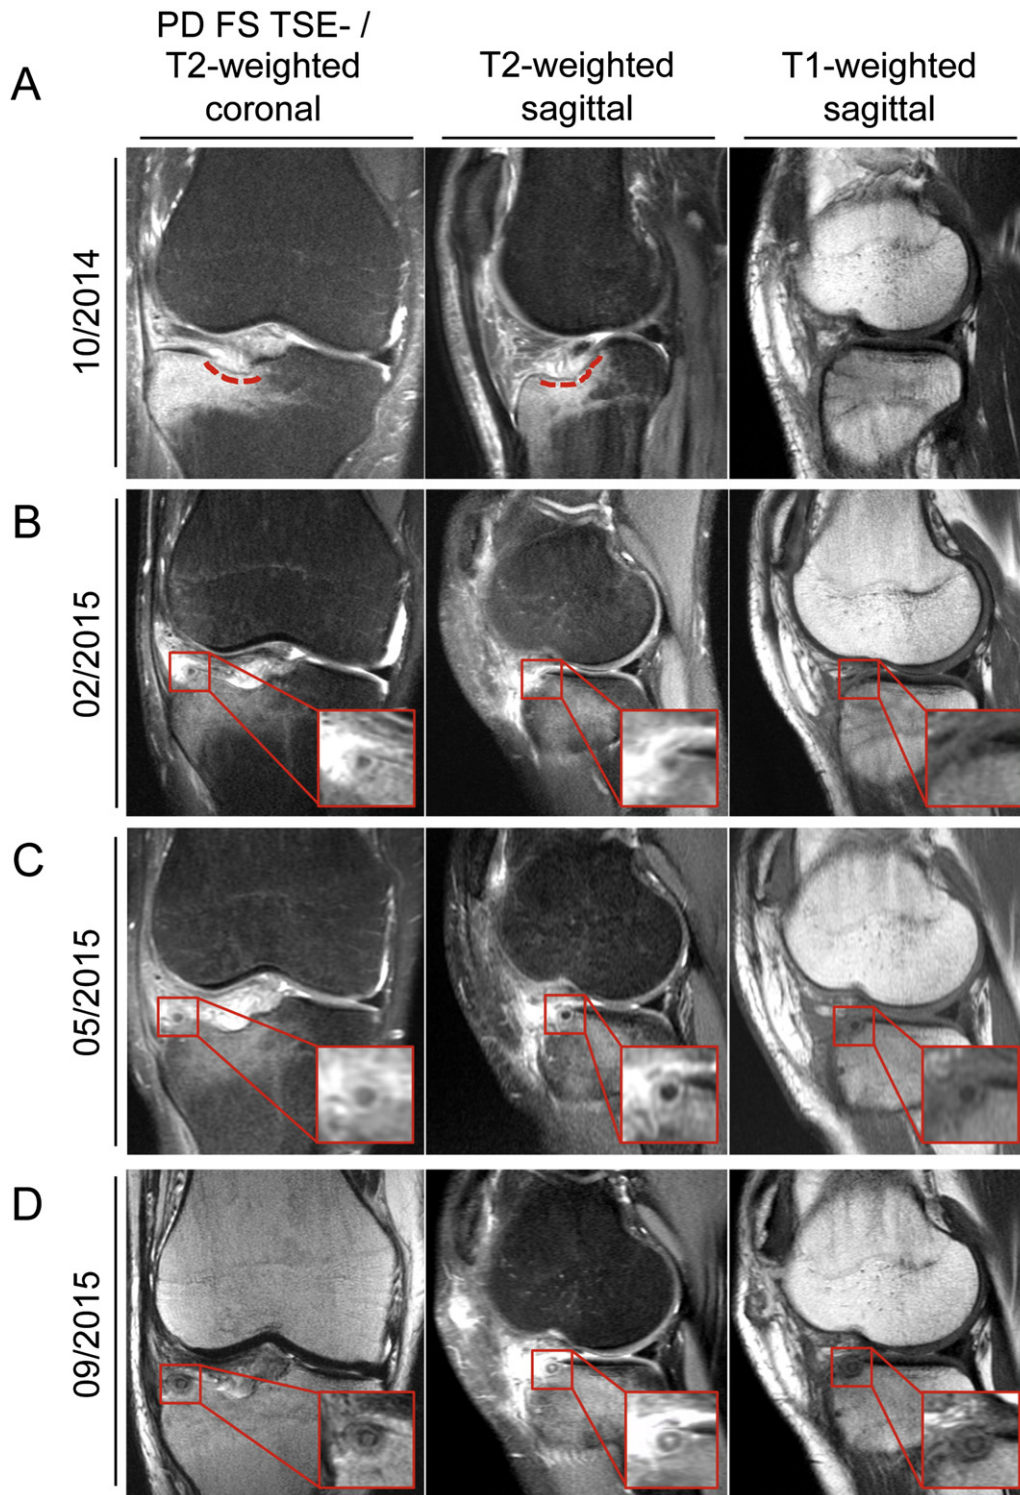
MRI specific characteristics of iaOO progression. Fat suppressed (FS), proton density (PD) weighted, turbo spin echo (TSE) MRI images show an ill-defined high intensity signal of the subchondral bone in the lateral tibia plateau without a specific focus. An old submeniscal bone impression in the antero-central region of the lateral tibia plateau can be seen (dotted line, A). Four months later, PD FS TSE- and T1-weighted TSE images show a poorly demarcated, semi-round lesion with a hypointense center and a diffusely enhanced signal surrounding the nidus (B). Another three months later, the central low signal and its rim enhancement became sharper. A minor, fusiform low intensity signal accompanies the hyperintense rim (C). In the final stage, the central nidus with its low central signal and a more sharply enhanced rim demonstrates a hyperintense center within the low signal nidus on all T1 TSE-, T2 TSE- and PD FS TSE-weighted sequences (D).
